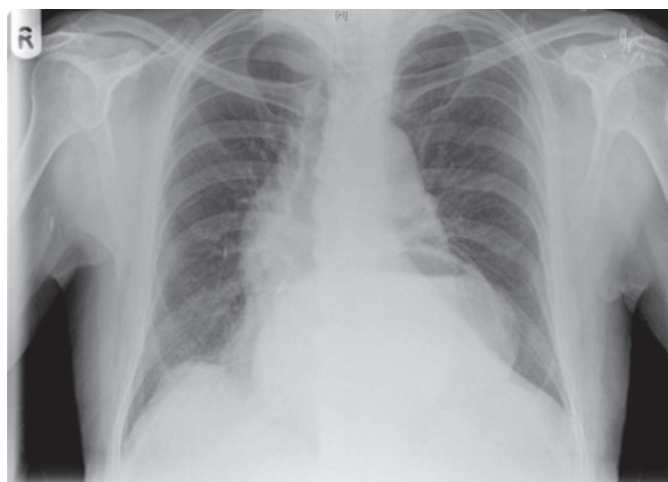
Chest X-ray showing a retrocardiac viscus with an air/fluid level.
